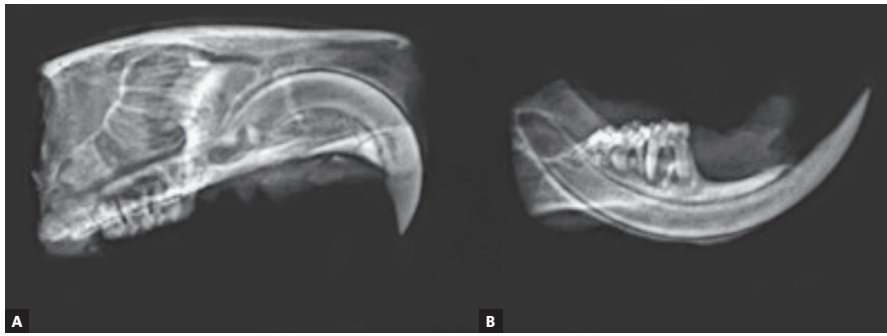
Radiographic images of the maxilla (A) and mandible (B), respectively, proving the presence of endodontic infection. It is evidenced a radiolucent area next to the peripapices of the molars that had their pulps exposed.
